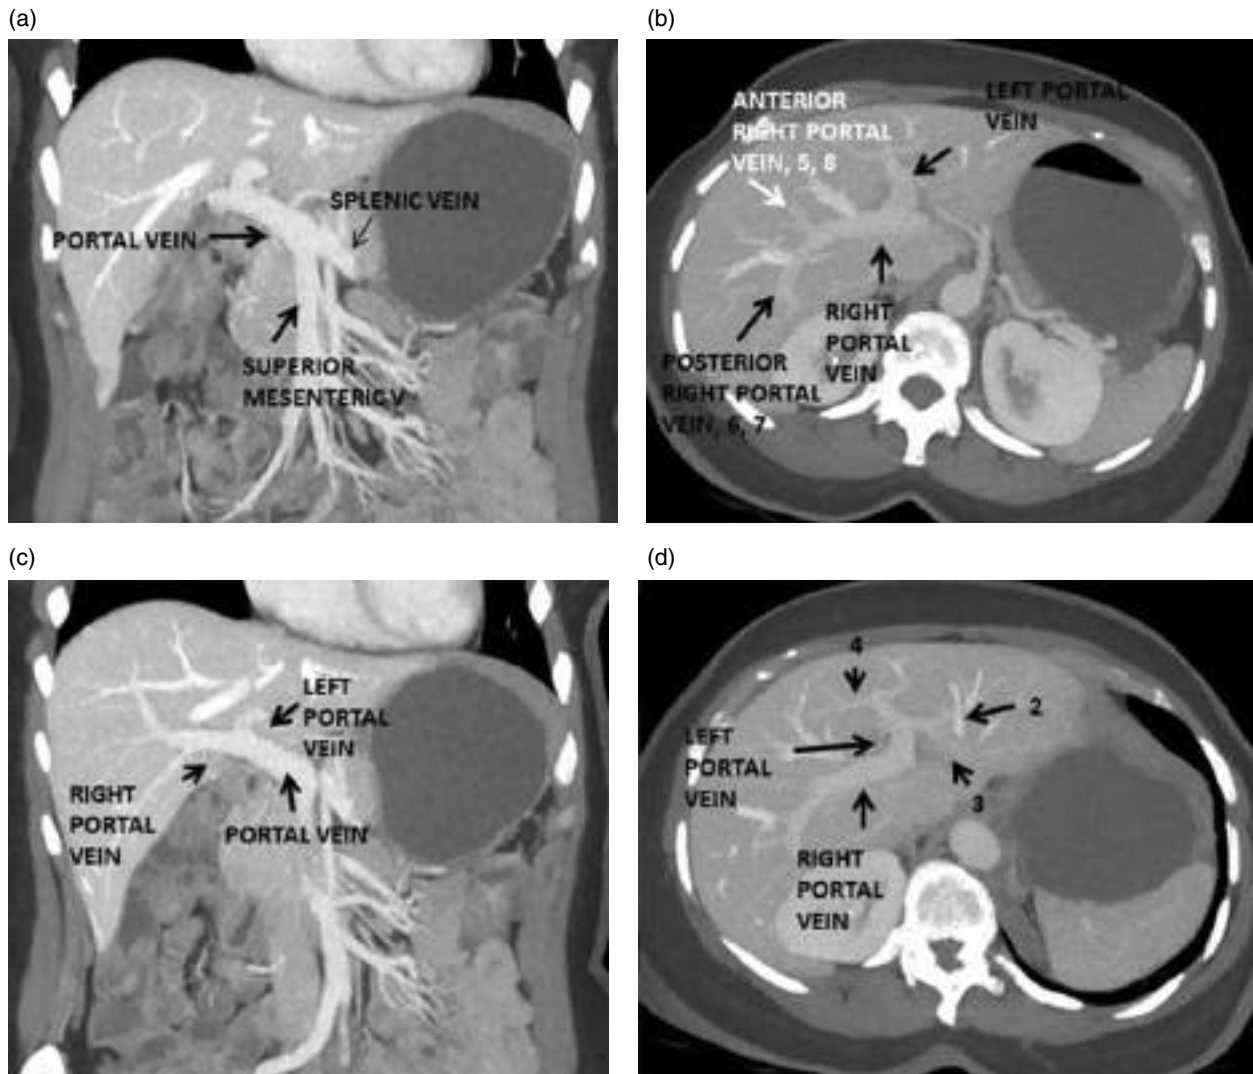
Main portal vein and intrahepatic branches. (a, c) Coronal contrast-enhanced MPR CT image (portal venous phase). (b, d) Axial contrast-enhanced CT image (portal venous phase).
